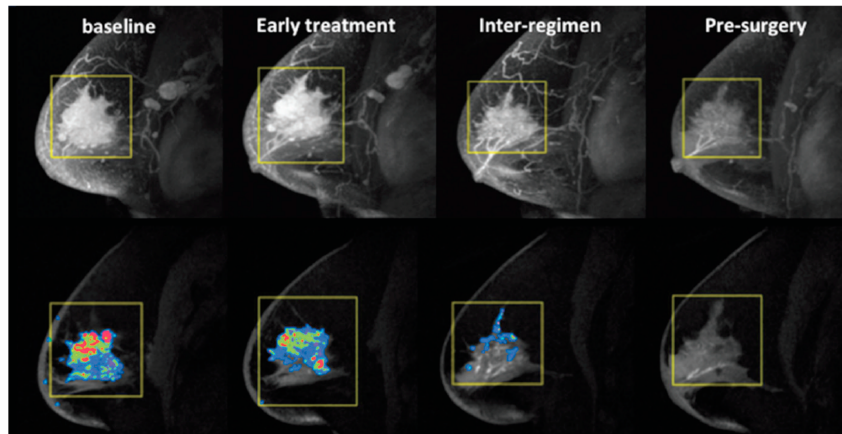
An example of using MRI functional tumor volume (FTV) to monitor a breast cancer patient during neoadjuvant chemotherapy. From left to right, FTV measurements were 48.5, 35.4, 5.6, and 0 cm³ at baseline, early treatment, inter-regimen, and pre-surgery time points, respectively [11].
